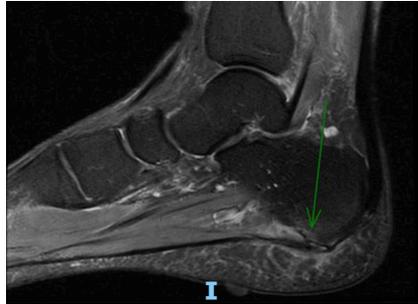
Sagittal T2-weighted images with fat saturation of the hindfoot, soft tissue, and per fascial edema associated with subcortical calcaneal bone edema (arrow).
